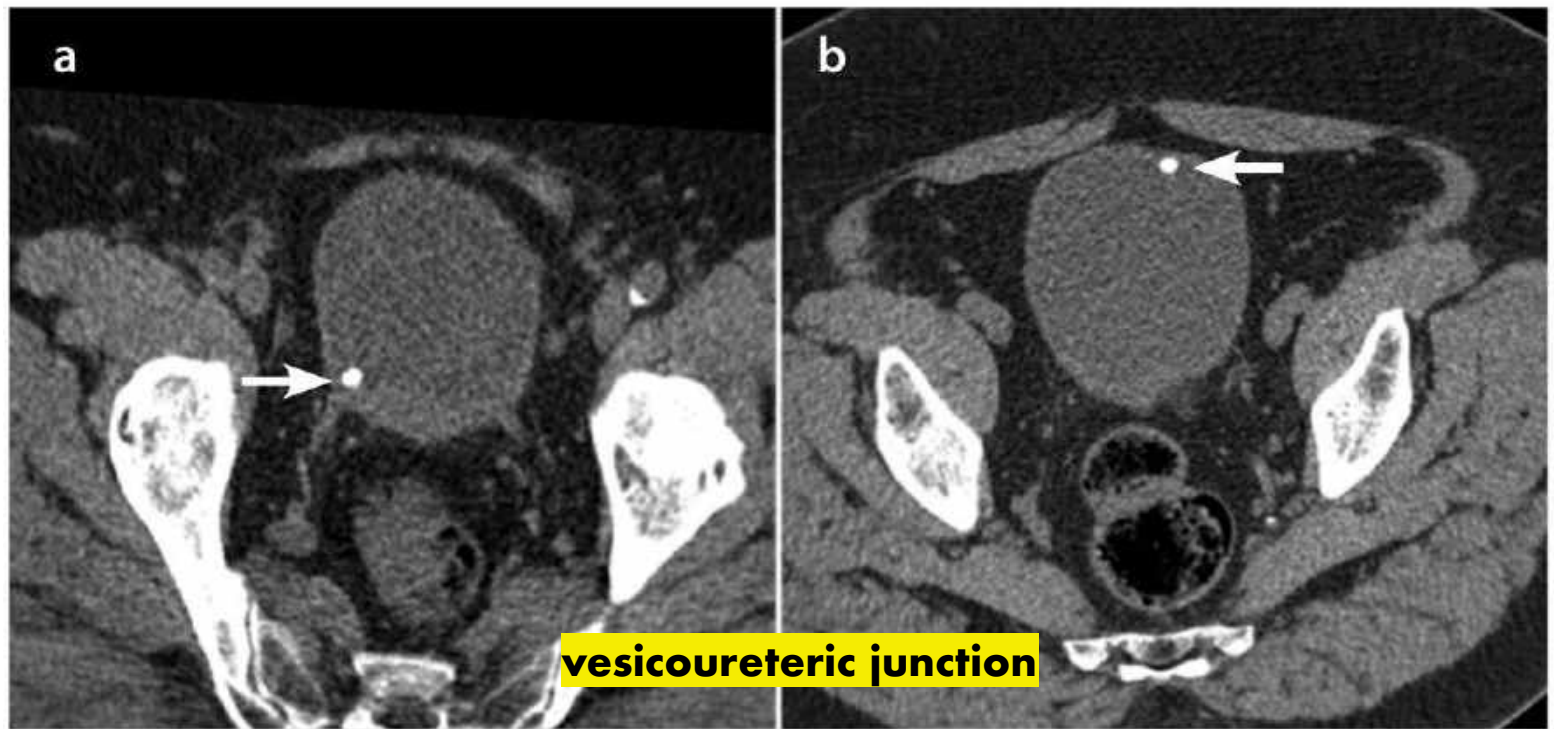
Axial non-contrast computed tomography. (a) In a supine position with a stone sitting at the right vesicoureteric junction (arrow). This is shown to have actually passed into the bladder on the prone image (b) performed at the same time (arrow).
